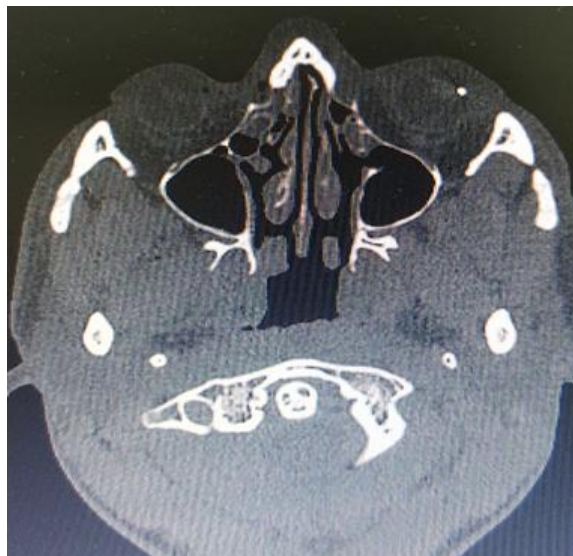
Axial CT scan of orbits showing the hyper dense area (foreign body) in the anterior chamber of the left eye.
